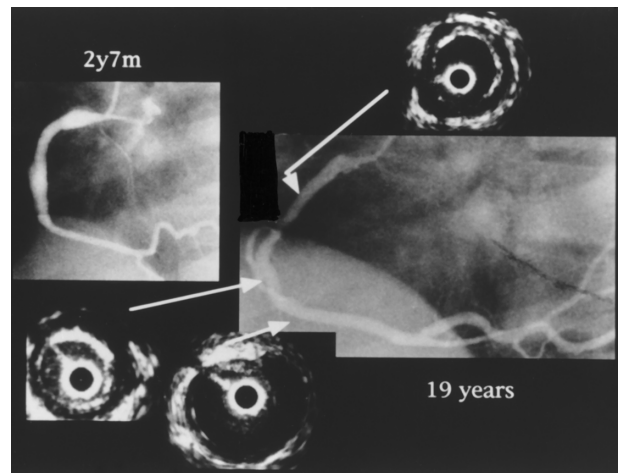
Coronary angiograms and intravascular ultrasound images. This 19-year-old patient had Kawasaki disease at the age of 2 year 7 months. In the first angiogram, the maximum diameters of the coronary arteries were as follows: Segments 1, 2, and 3 were 5.2, 6.5, and 2.5 mm, respectively. By IVUS, the maximum intima–medial thicknesses of the vascular wall were as follows: Segments 1, 2, and 3 were 1.34, 1.93, and 0.21 mm, respectively.
